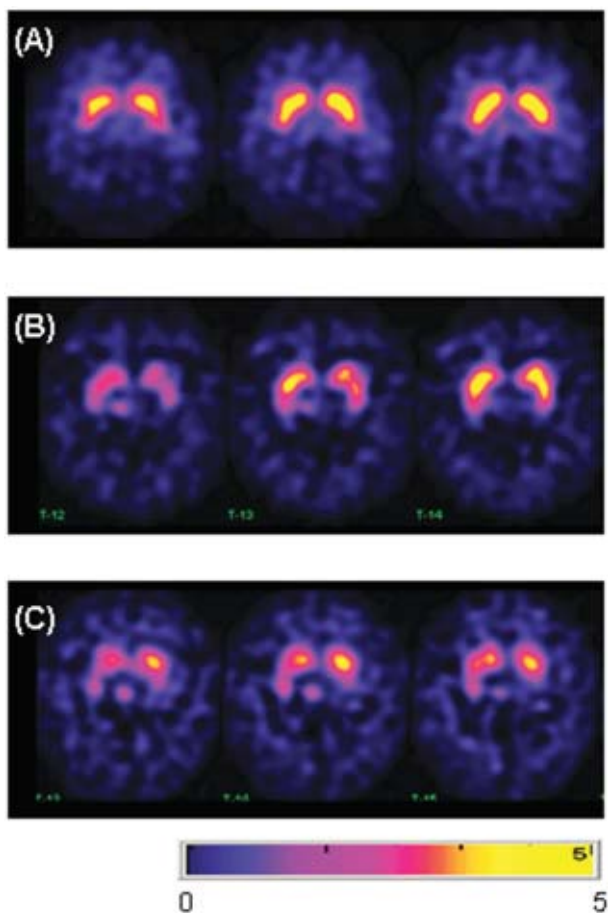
[^{123}I]-FP-CIT brain SPECT images of dopamine transporter (DAT) taken from the patient (A), a healthy control (B) and a Parkinson's disease patient (PD)(C).
